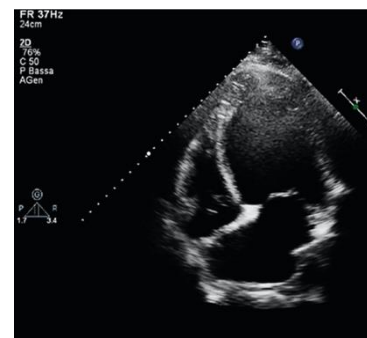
transthoracic echo in apical 4-chamber view, showing extreme remodelling of the heart chambers. Retrieved from Gil *et al.*, 2016.
